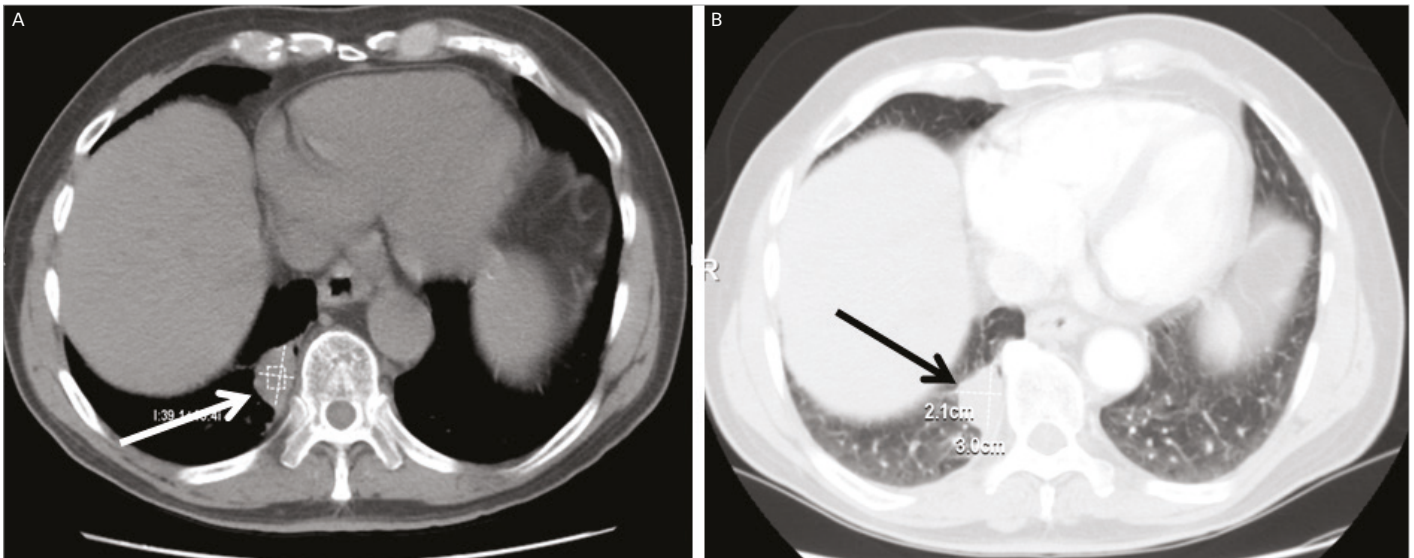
Computed tomography scan—right paravertebral mass (arrows)
